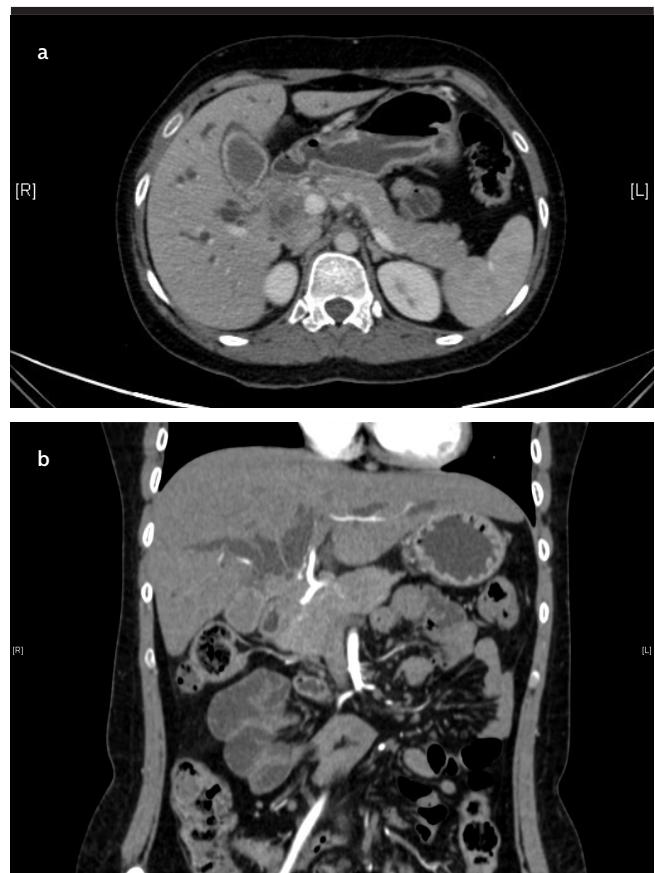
a, b. CT showing perihilar mass lesion with bilobar dilation of intrahepatic biliary radicals
